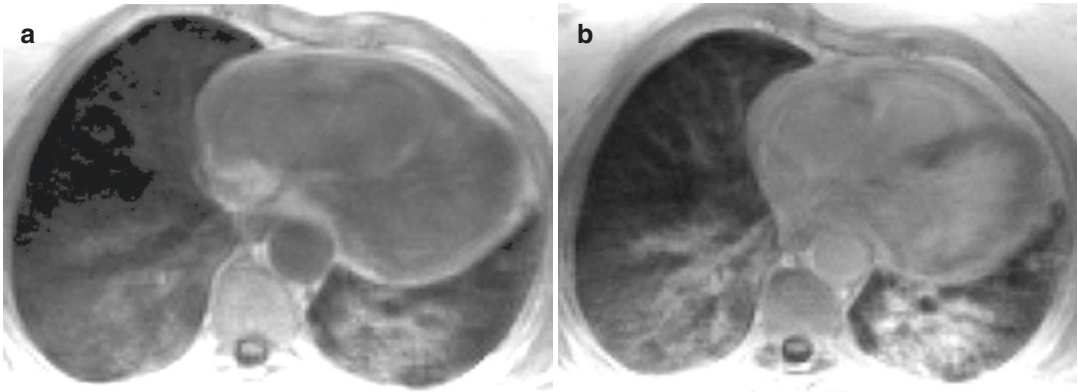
A 70-year-old female patient with interstitial lung disease associated with systemic lupus erythematosus. Pre-contrast (a) and post-contrast (b) T1-weighted 3D
